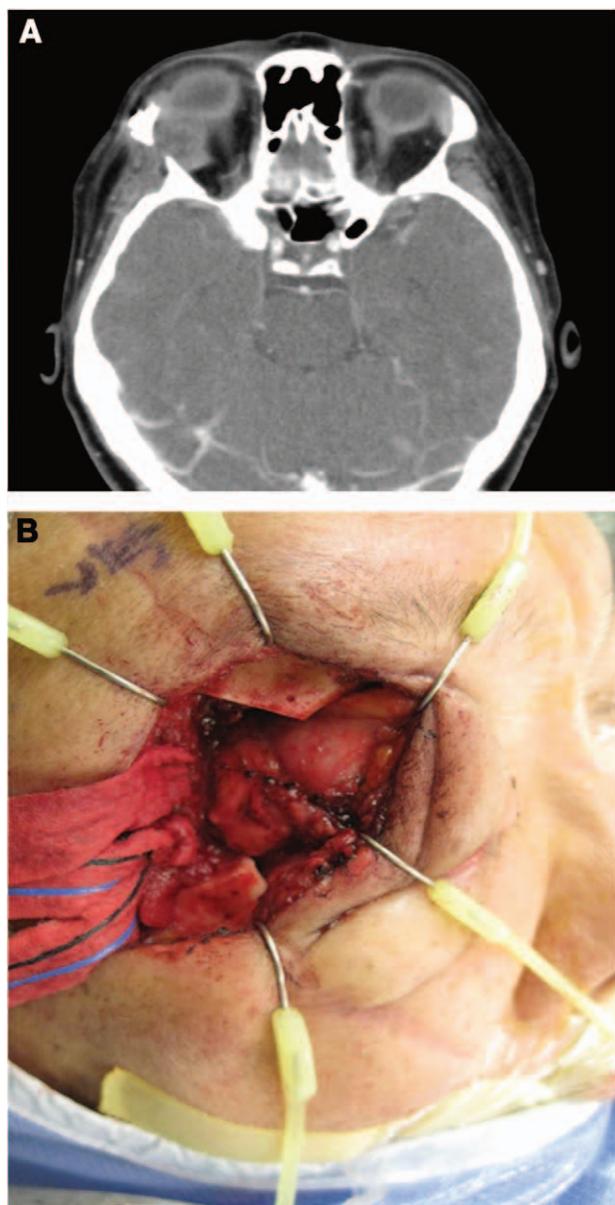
A, CT axial image of lacrimal gland adenoid cystic carcinoma, which was excised through a lateral orbitotomy (B).
